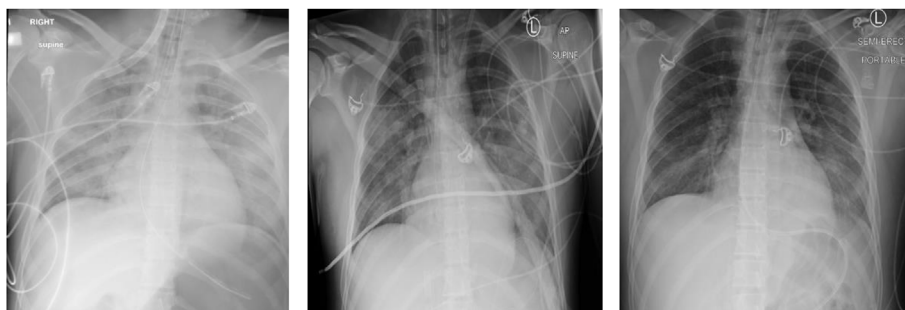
Chest radiography over clinical course.
